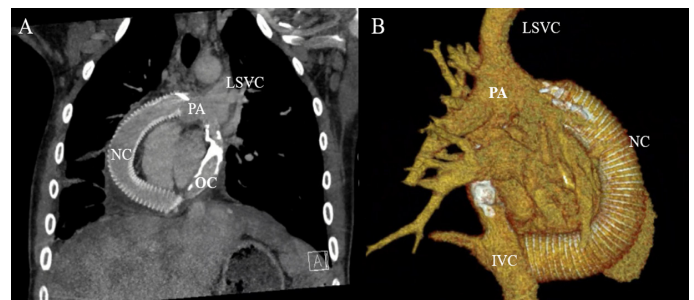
Follow-up computed tomography scan: (A) coronal cut, and (B) 3-dimensional reconstruction (posterior view) showing widely patent new conduit connections and the diffusely calcified old conduit *in situ*
